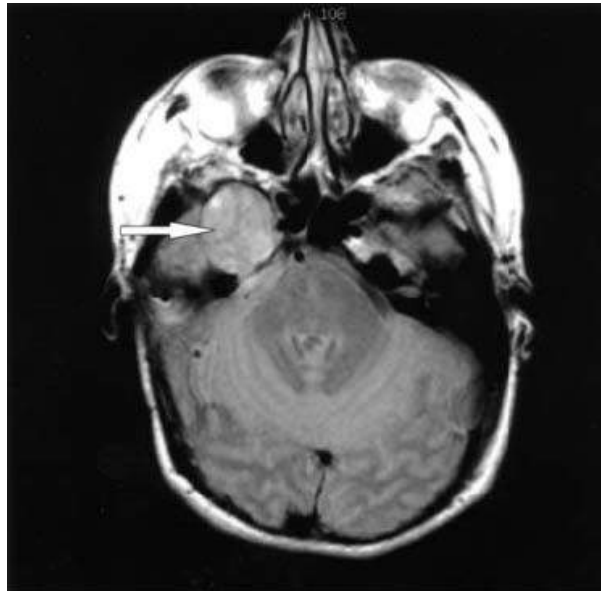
Axial T1-weighted un-enhanced MRI scan showing a recurrent tumour in middle cranial fossa. There is no evidence of mass defect, midline shift or hydrocephalus.
